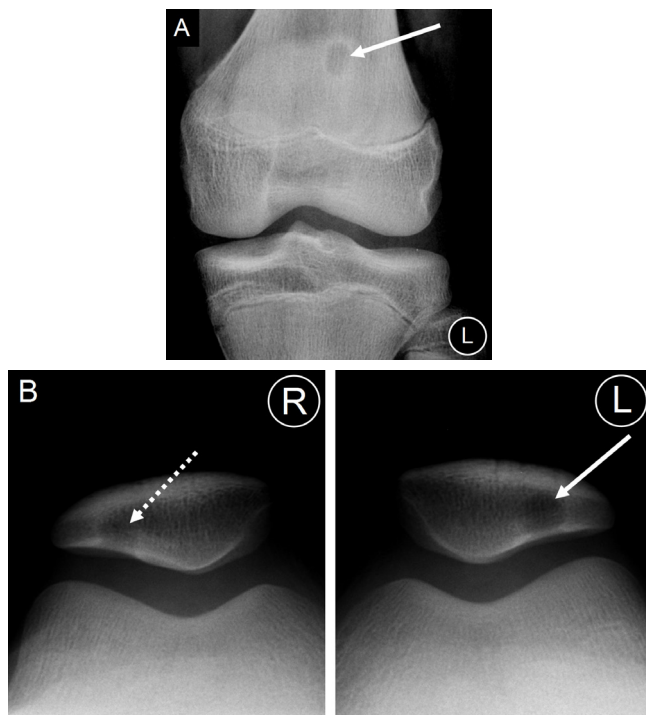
Frontal radiograph of the left knee (A) and skyline radiographs of both knees (B).
